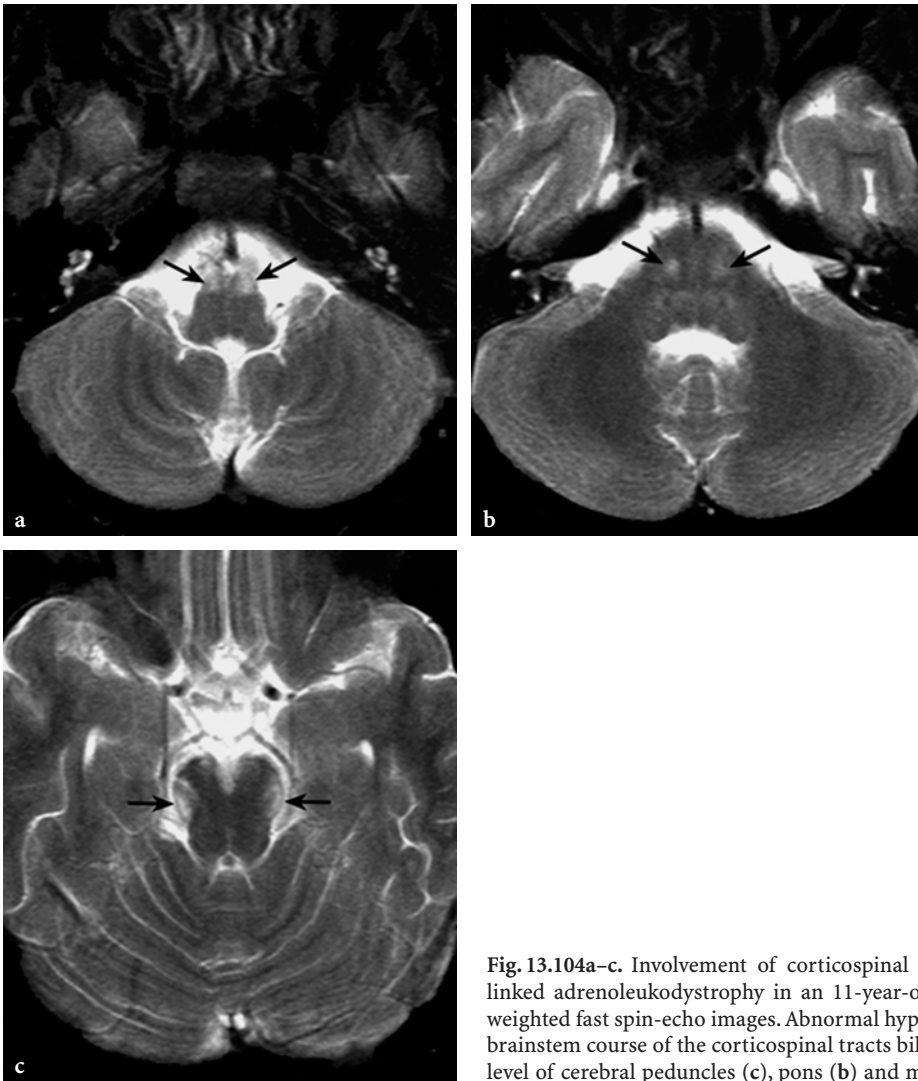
Involvement of corticospinal tracts within brainstem in X-linked adrenoleukodystrophy in an 11-year-old male patient. a-c Axial T2-weighted fast spin-echo images. Abnormal hypersignal is seen along the entire brainstem course of the corticospinal tracts bilaterally (*arrows*), notably at the level of cerebral peduncles (c), pons (b) and medulla oblongata (a)
